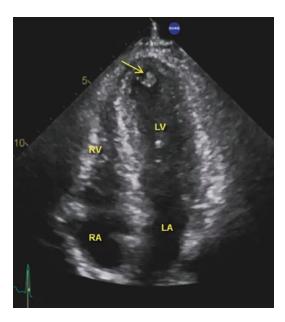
Apical four-chamber view in a patient post anterior myocardial infarction. A circular thrombus is seen at the apex
